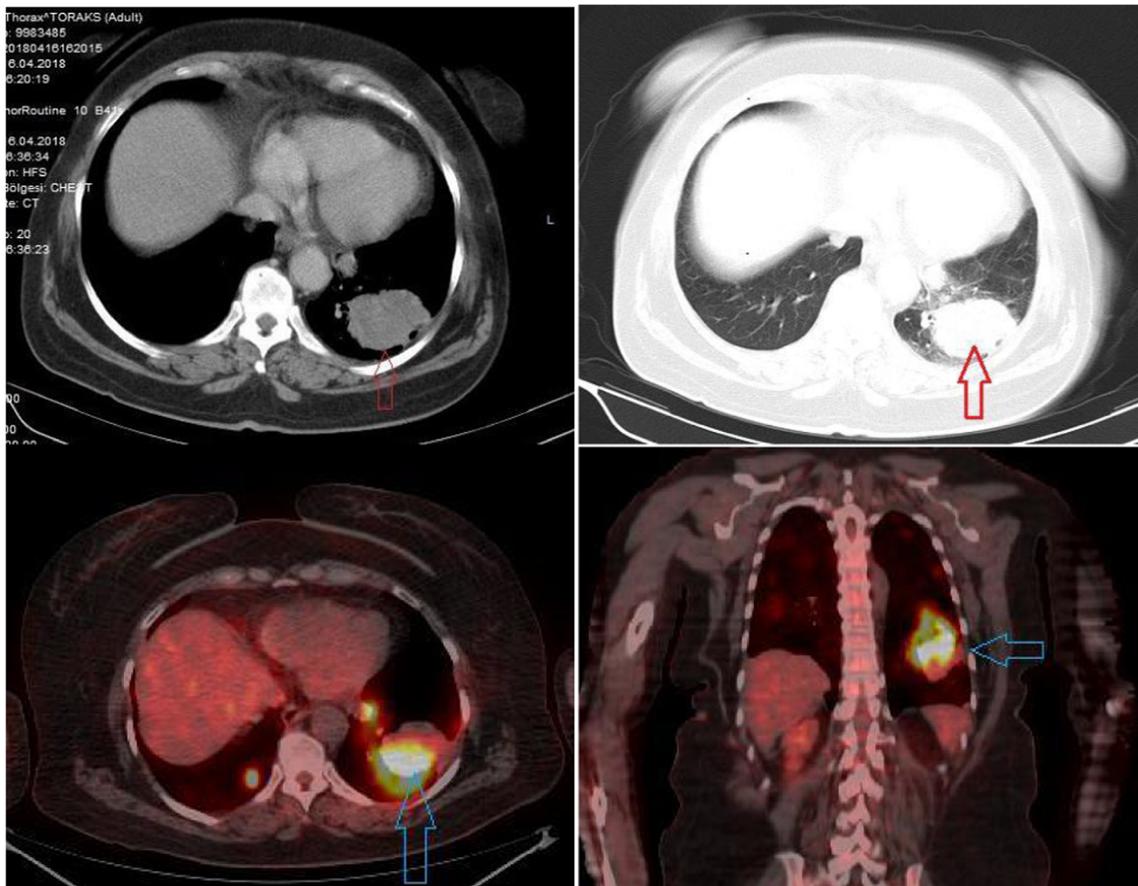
Computed tomography (CT) and positron-emission tomography/CT scan of the mass, showing left lung metastasis (indicated with arrows)
